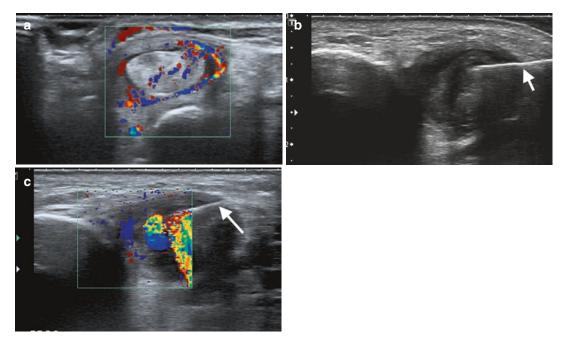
A 59-year-old female patient with marked posterior tibialis (PT), tendinosis, and tenosynovitis. (a) Transverse ultrasound level of the medial malleolus demonstrating thickened heterogenous tendon and distended
